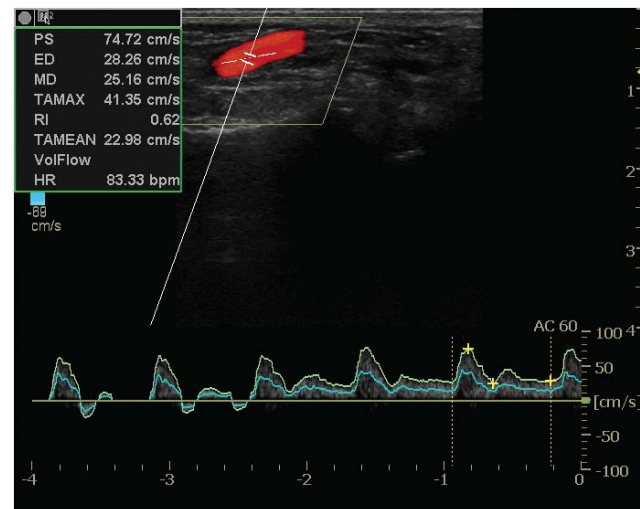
Pulse wave doppler spectrum of a normal left radial artery prior to vascular access construction. Upon opening the clenched fist, the resistive index (RI), decreases from 1 (no end diastolic flow) to 0.62
